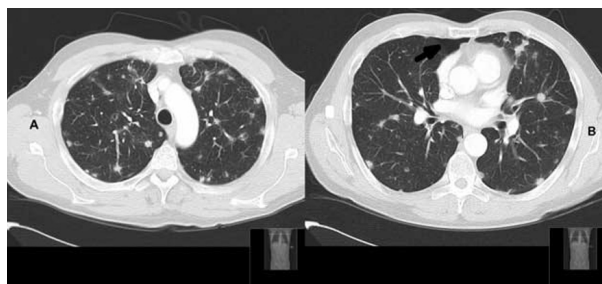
A, Chest CT scan revealing multiple bilateral variable-sized cavitating pulmonary nodules. B, Chest CT scan revealing a small asymptomatic pneumothorax (arrow).
